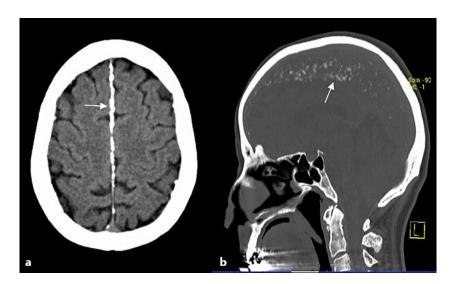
Calcification of the falx cerebri. Brain computed tomography scan showing lamellar calcifications of the falx cerebri (white arrow). a Axial view. b Sagittal view.
